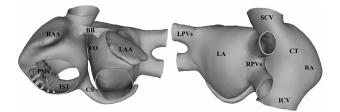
3D modelo of human atrium, including: Left (LA) and right (RA) atrial chambers, pectinate muscles (PMs), Bachmann's bundle (BB), crista terminalis (CT), fossa ovalis (FO), isthmus (IST), left (LAA) and right (RAA) appendages, coronary sinus (CS), right (RPVs) and left (LPVs) pulmonary veins, superior (SCV) and inferior (ICV) caval veins.
